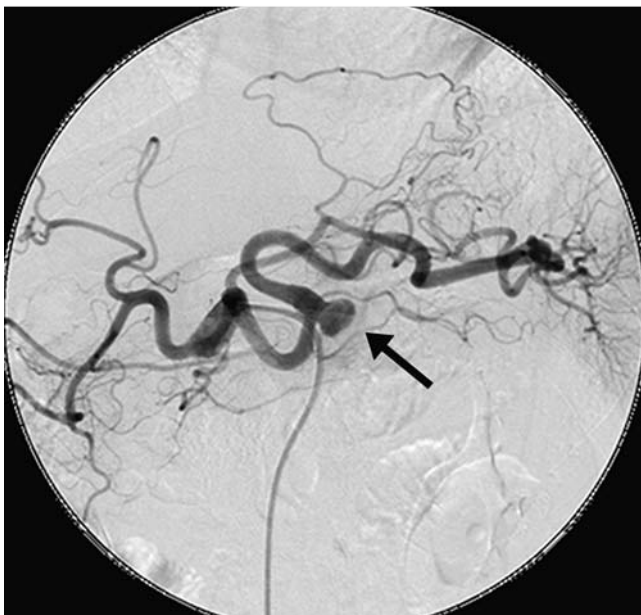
Image taken during abdominal angiography showing the splenic artery aneurysm (arrow) that had appeared on computed tomography (CT) scanning and endoscopic ultrasound (EUS) to be a probable tumor of the pancreatic body.
